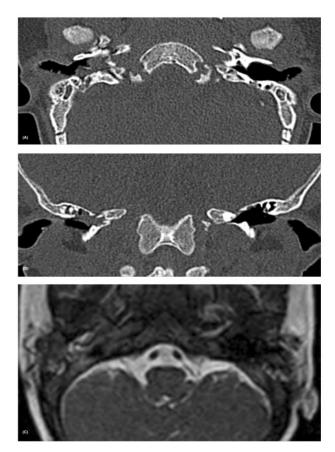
(A & B) Axial and coronal CT images bone window sitting & [C] Axial T2WI: Complete absence of inner ear structures with non-visualized cochlea, vestibule or semicircular canals on either side. Note obliterated right middle ear cavity by high density inflammatory material which appreciates intermediate signal in T2WI, a pattern suggestive of congenital cholesteatoma. This inflammatory material is surrounding the middle ear ossicles with erosion of the scutum and bulging into the tympanic membrane. The ossicles are small and could be eroded by the inflammatory debris while the left ossicular chain is clearly identified.
